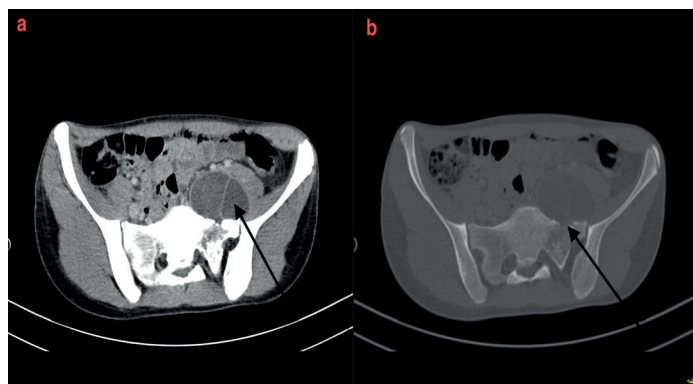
Contrast enhanced abdominal CT
